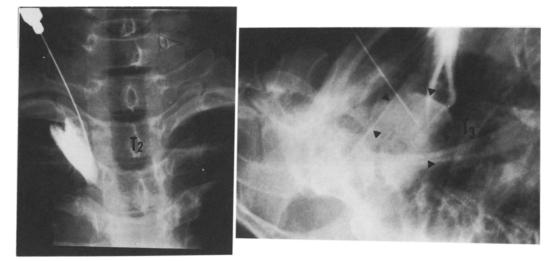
A-P and lateral X-ray films of TSGB by the anterior approach.
